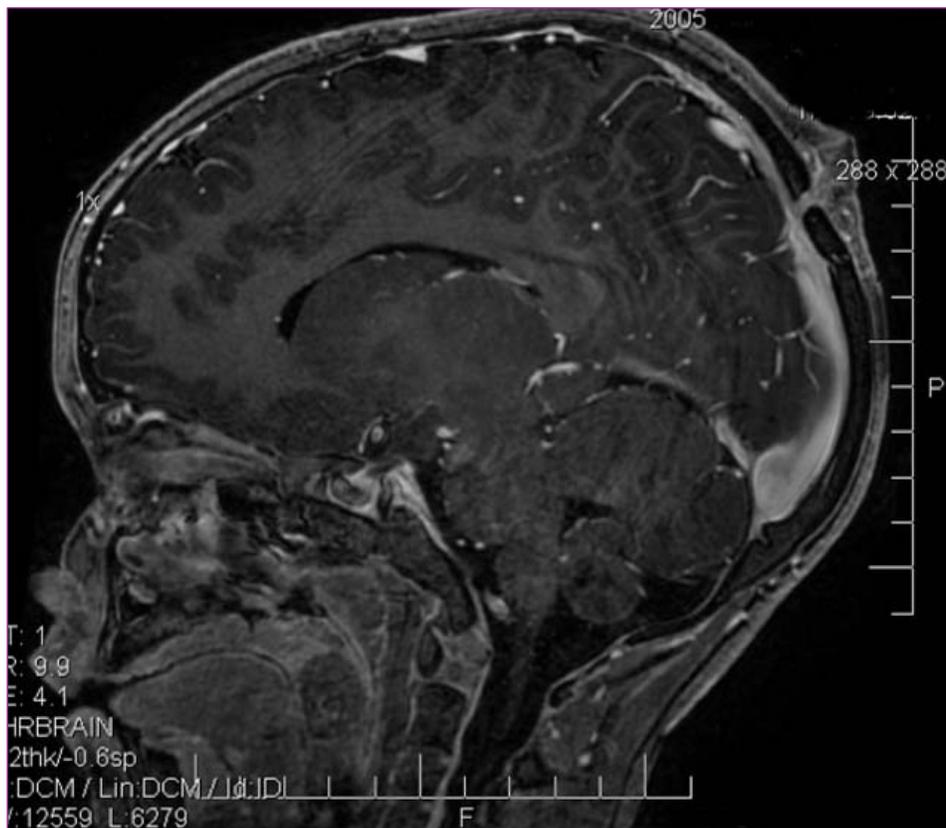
MRI imaging of patient's scalp displaying intracranial extension.
